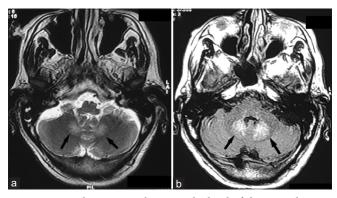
MRI brain in axial view at the level of the pons showing signal hyperintensities (arrows) in bilateral dentate nuclei on (a) T2-weighted imaging and (b) FLAIR imaging.
